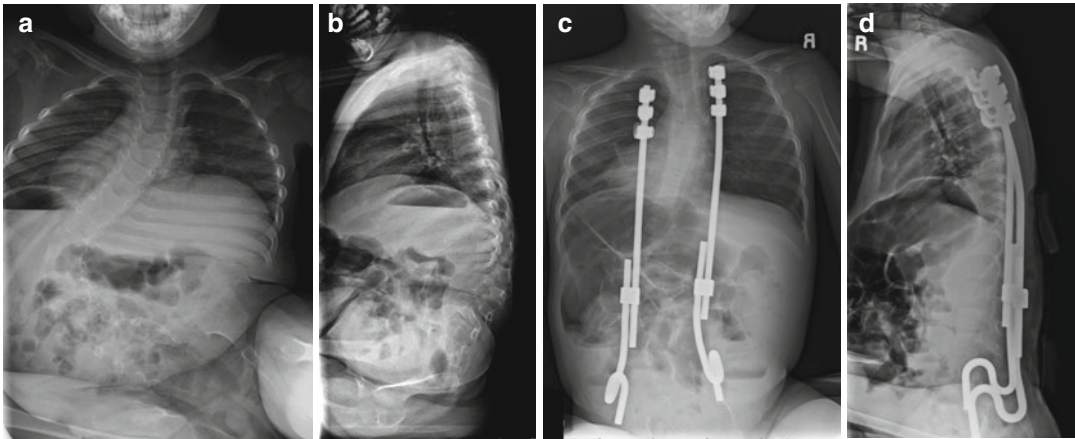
(a–d) PL presented at 15 months of age with a 90° scoliosis and 40° pelvic obliquity. He underwent spinal cord detethering, but as anticipated with a curvature of that magnitude, there was continued progression and loss of seating balance. The spinal radiographs at 3 years
